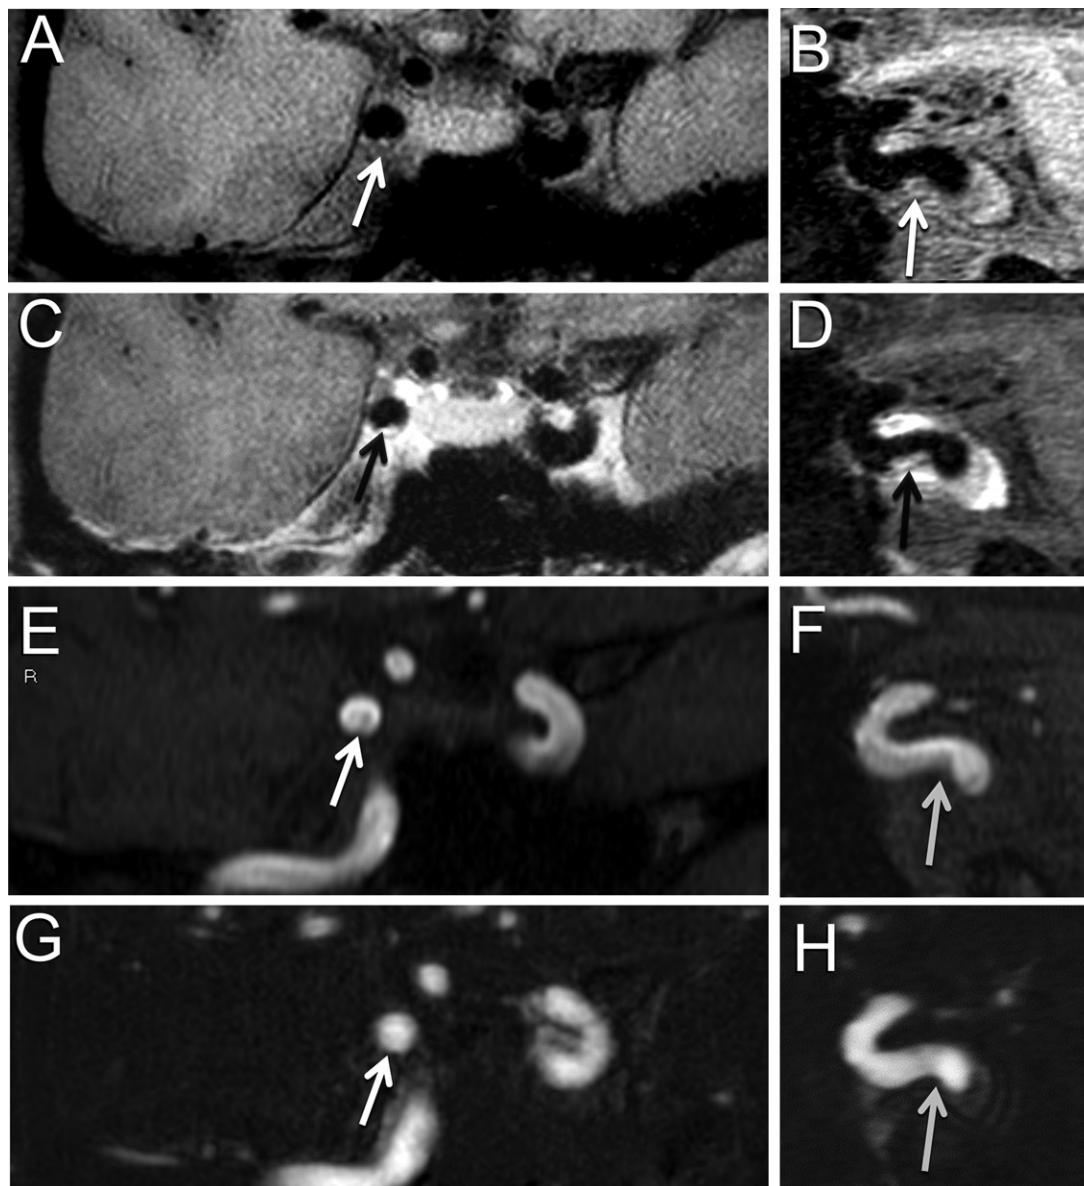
Incomplete blood flow suppression mimicking atherosclerotic plaque in a 53-year-old woman with a history of vision loss. (A) Coronal three-dimensional vessel wall MRI scan acquired through the short axis of the cavernous segment of the right internal carotid artery with (B) a long-axis reconstruction and (C, D) repeated MRI scans after administration of a gadolinium-containing contrast agent show what appears to be focal eccentric thickening with avid enhancement along the inferior wall suggesting plaque (arrow). (E, F) Reconstructions of a time-of-flight MR angiography (MRA) scan matching the short-axis (E) and long-axis (F) orientations shown above show similar but more subtle artifacts due to flow disturbances (arrow). (G, H) Contrast-enhanced MRA reconstructions matched with E and F reveal lumen patency without irregularity, enabling confirmation of the suspected wall thickening as artifactual (arrow).
